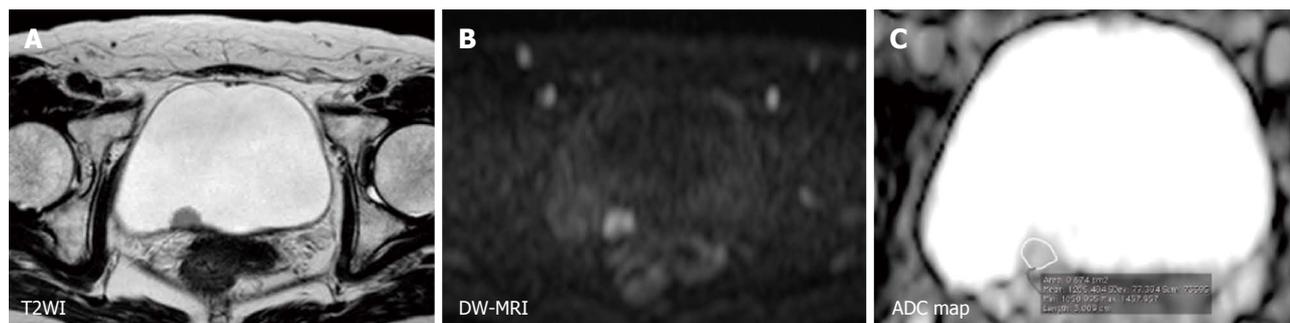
Magnetic resonance images of a 52-year-old woman with non-muscle-invasive bladder cancer (urothelial cancer, pTa, grade 2). A: T2WI shows a hypointense tumor at the posterior wall; B: DW-MRI displays the tumor as a high-signal mass; C: The corresponding ADC map demonstrates a lesser degree of restricted diffusion. The mean ADC value with the ROI positioned not extending over the tumor is 1.21×10^{-3} s/mm². DW-MRI: Diffusion-weighted magnetic resonance imaging; ADC: Apparent diffusion coefficient.
